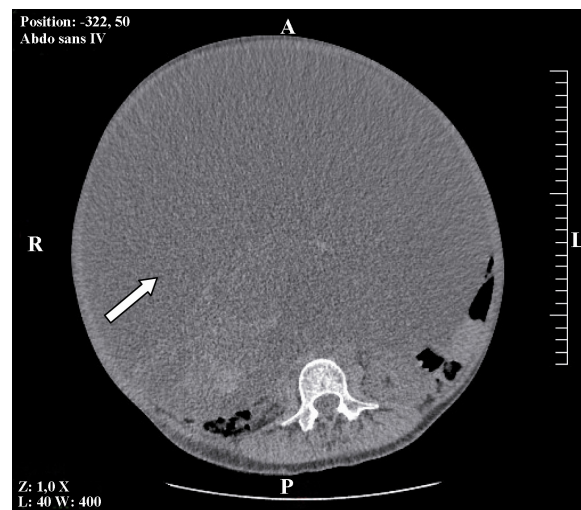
Abdominal axial CT-scan showing a voluminous ovarian cyst (white arrow)
